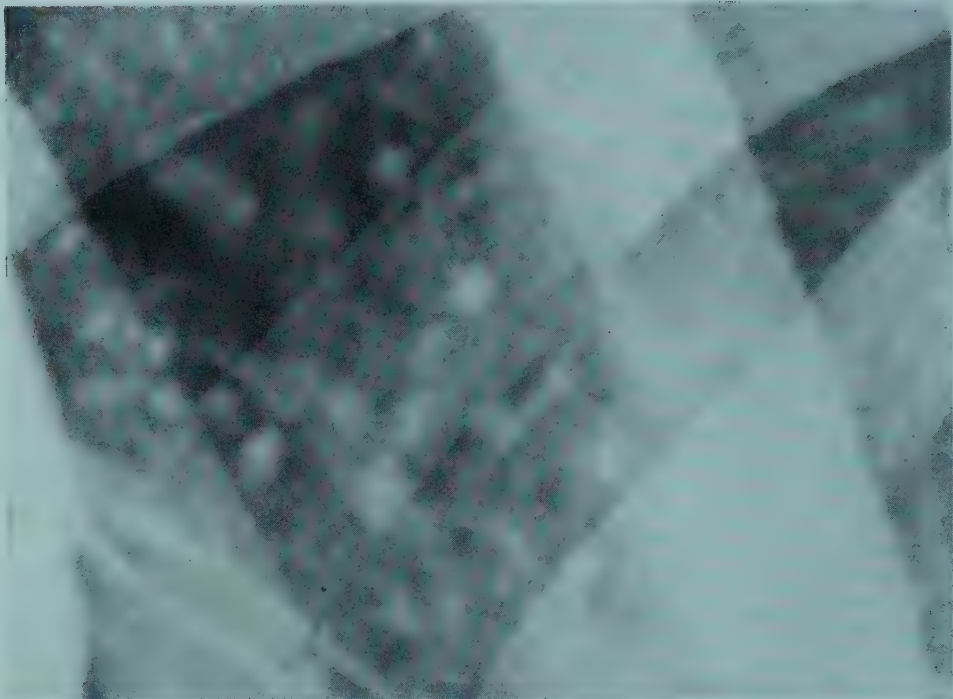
/11. Lower lung field radiograph. Foci of ossification in mitral stenosis.
